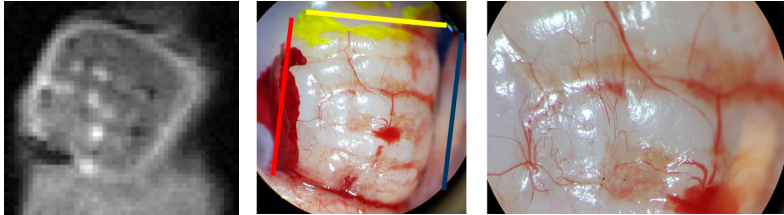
Dynamic contrast-enhanced MRI (DCE-MRI) image of the implanted construct obtained after intravenous administration of the contrast agent (Left). The white spots in the DCE-MRI image are areas of increased contrast signal intensity in the construct corresponding to the location of the grid holes (Middle and Right)
